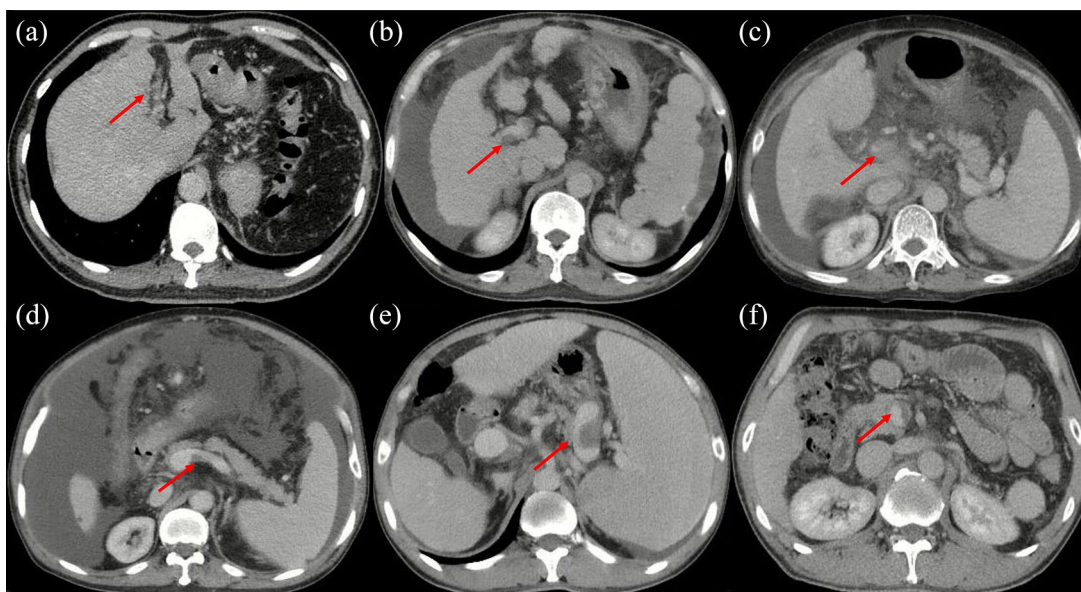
Contrast-enhanced CT images. (a) fibrotic cord within LPV (red arrow); (b) partial thrombosis within RPV (red arrow); (c) complete thrombosis within MPV (red arrow); (d) partial thrombosis within the confluence of SMV and SV (red arrow); (e) complete thrombosis within SV (red arrow); and (f) mural thrombosis within SMV (red arrow).
